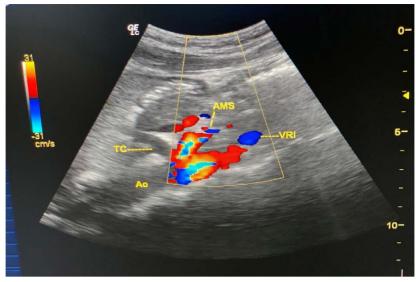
Abdominal Doppler. Patent left renal vein. LRV: Left renal vein. SMA: Superior mesenteric artery, Ao: Aorta.
